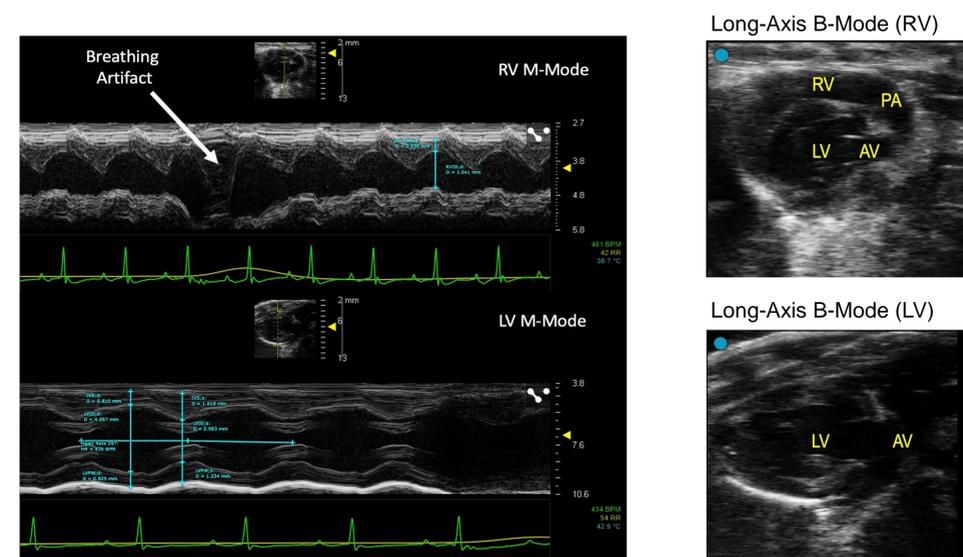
Example echocardiography imaging and measurements.
